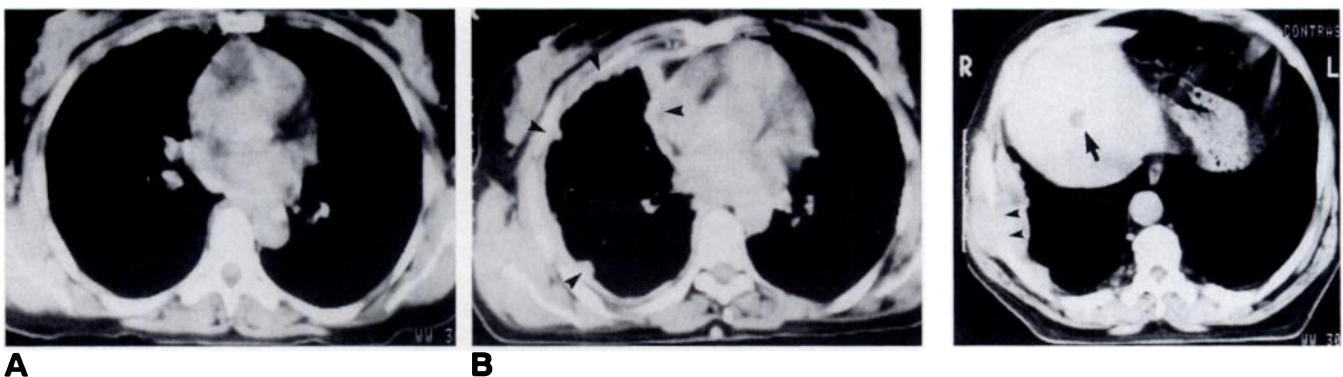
50-year-old woman with previous environmental exposure to asbestos. A, CT scan obtained because of vague chest discomfort shows normal findings. B, CT scan at approximately same level 2 years later shows irregular thickening of mediastinal and costal pleura (arrowheads) and volume loss of right hemithorax. Assessment of pericardial invasion was difficult because of contiguous pleural involvement. Malignant pleural mesothelioma was diagnosed by pleural biopsy.
